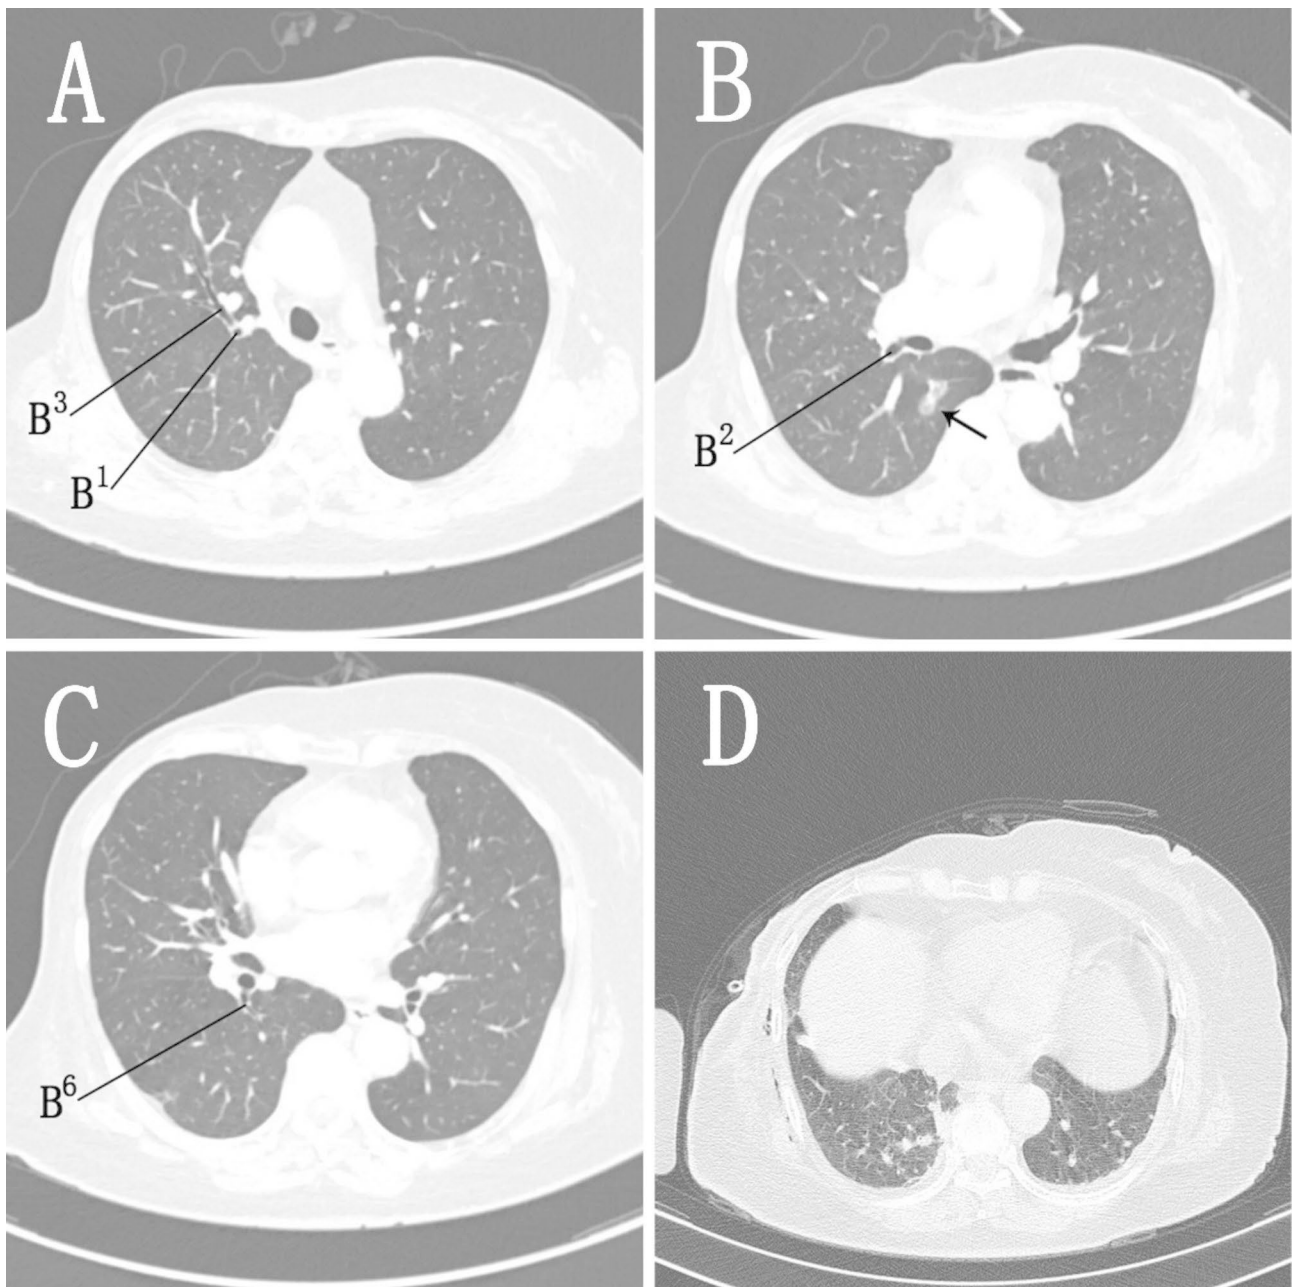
A+B+C, Preoperative lung CT; a mixed ground-glass nodule (arrow) measuring approximately 17 mm × 8 mm with a CT value of -700 HU was observed in the posterior segment of the right upper lobe. D, Postoperative lung CT, computed tomography
